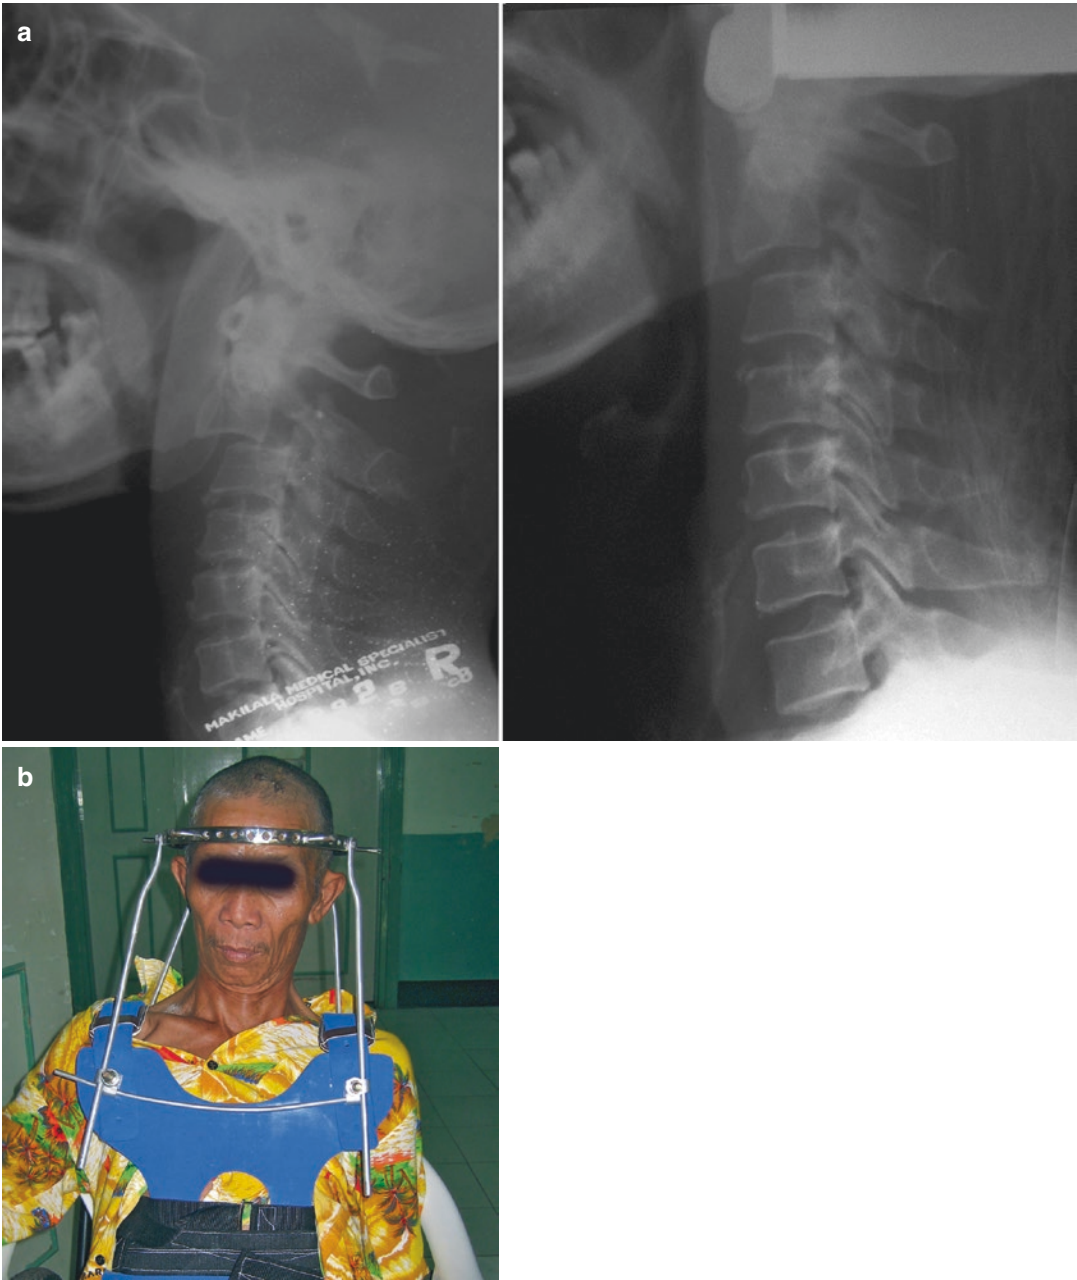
(a) *Left*: lateral X-ray of C2 hangman's fracture with spondylolisthesis of C2 on C3. *Right*: acceptable reduction in halo vest. (b) Patient comfortable in halo
